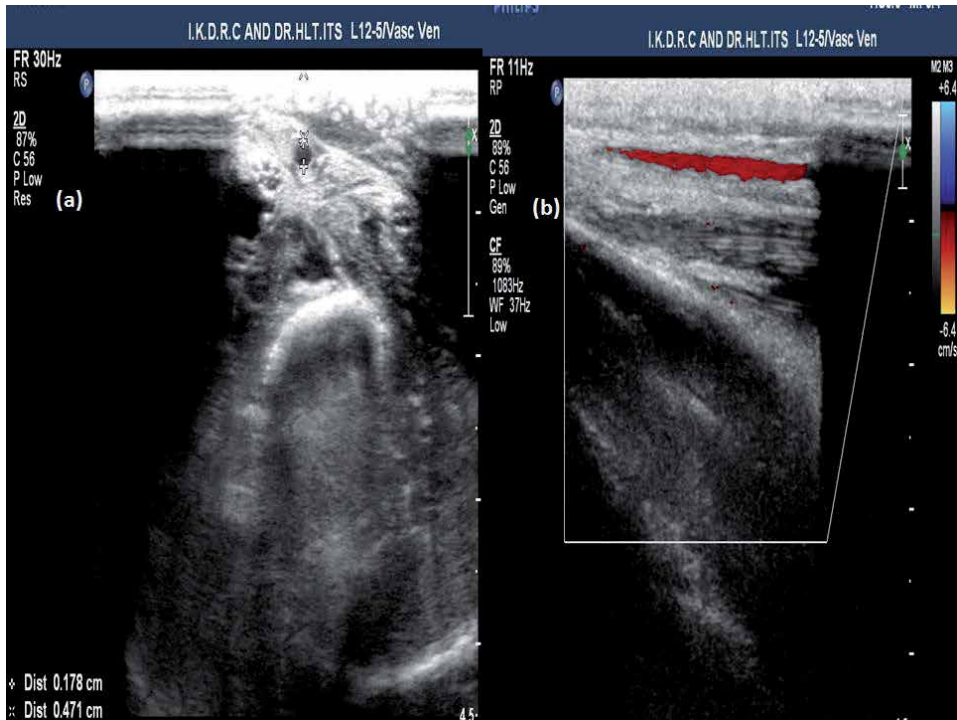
(a) Gray mode image showing narrow Cephalic vein in forearm with internal lumen diameter 1.8 mm and depth from skin level measuring about 4.7 mm and (b) patent lumen on color doppler study.
